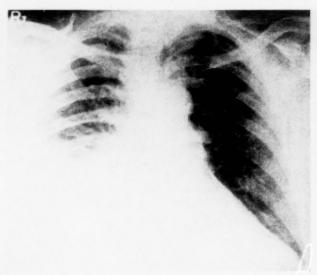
Patient L. L. Roentgenogram taken on the fourth day of illness. Consolidation of lower lobe of right lung is evident.
